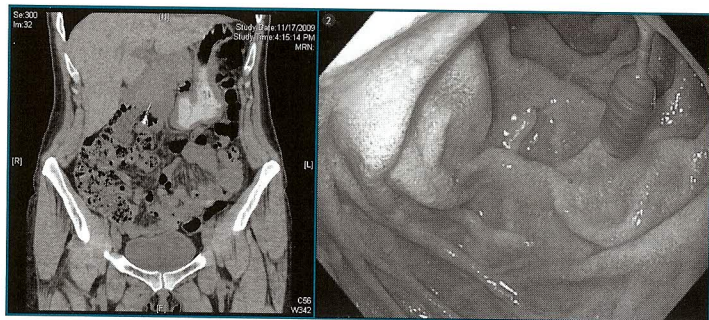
CT scan with linear needle-like foreign body (endodontic file) identified within the third portion of the duodenum.
